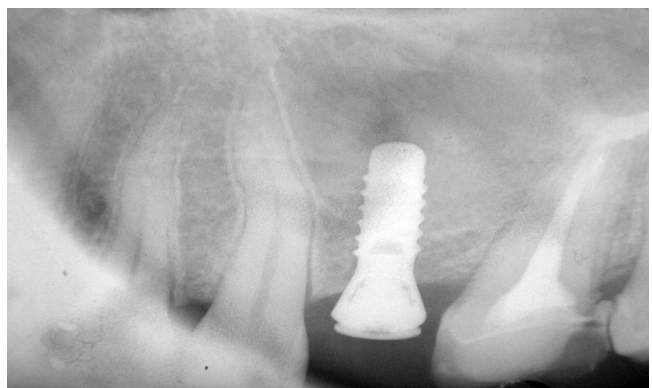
X-ray immediately after surgery.
